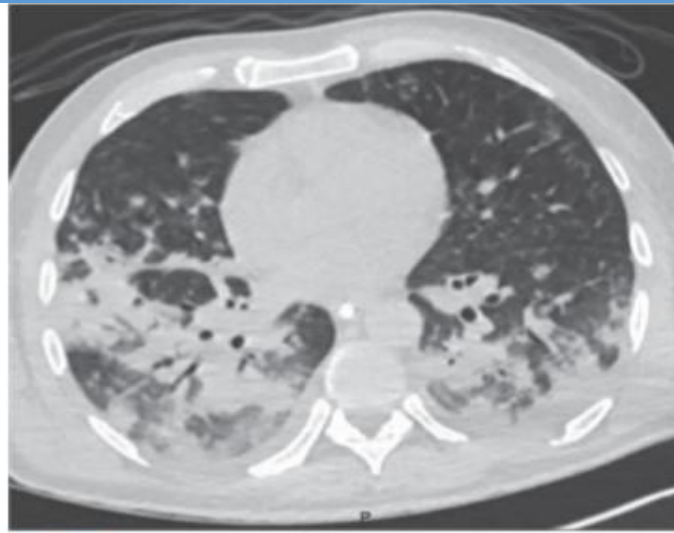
CT scan of the thorax in a patient with severe ARDS. Note the pathology is mainly in the dorsal (dependent) parts of the lung.
